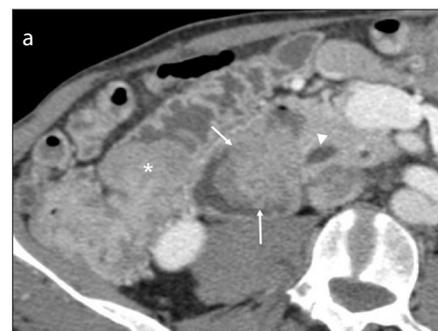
a, b. A 65-year-old man with juvenile polyposis syndrome (mutation in DPC4 - SMAD4) who had undergone multiple surgical procedures for recurrent subocclusive episodes. Curved-axial reconstructed contrast-enhanced CT image (a) and coronal-T2 weighted image (b) show an intraluminal duodenal polyp (arrows) causing moderate bile duct dilation (arrowhead). Note the colonic polyp (asterisk) in CT image (a).
